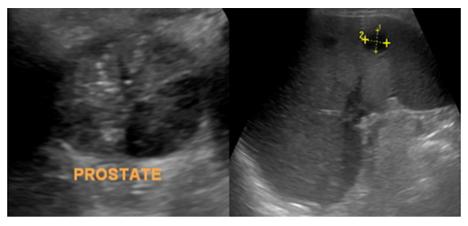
44 year old male diagnosed with melioidosis, transabdominal ultrasound demonstrates heterogenous parenchyma of the prostate with multiple hypoechoic foci (left) and spleen with multiple hypoechoic collections noted within (right).
